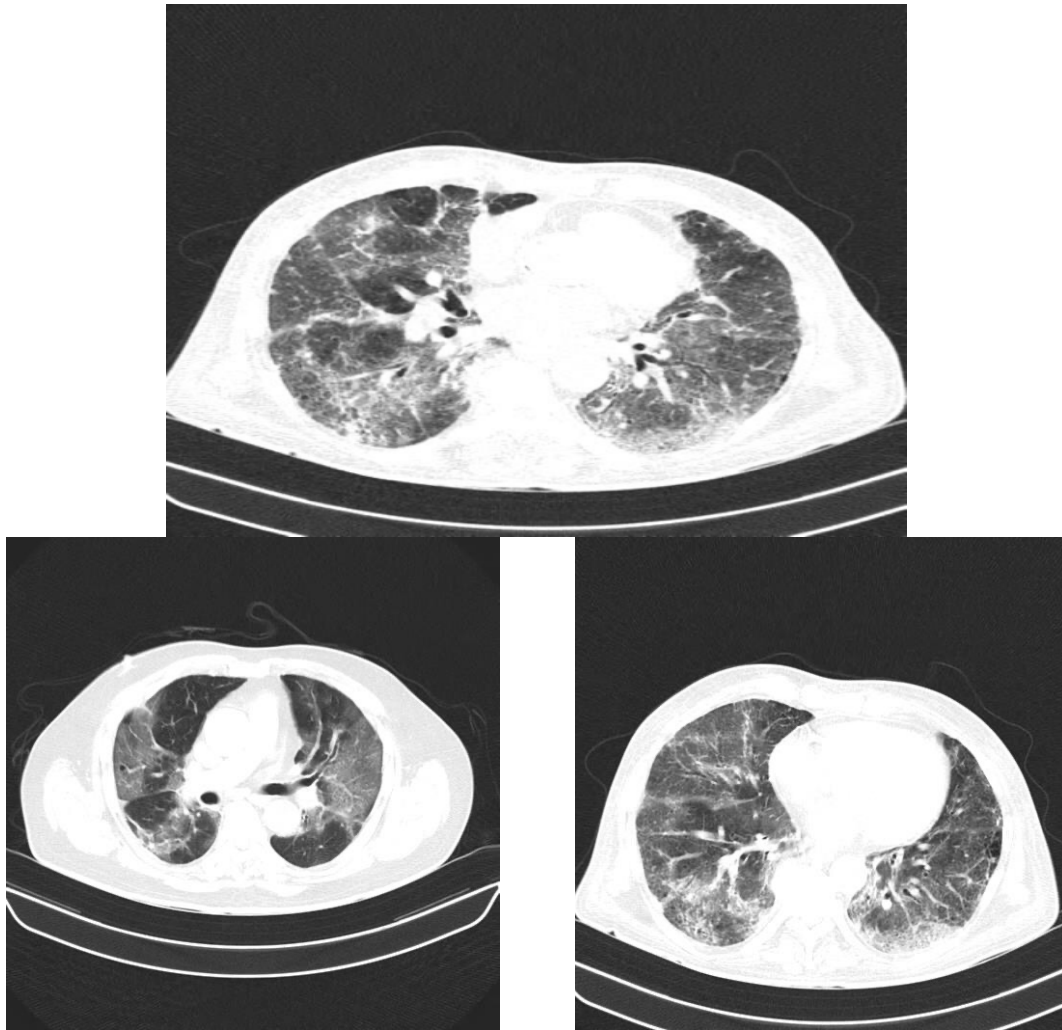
CT manifestations of covid19 disease a) ground glass opacities b) consolidation c) consolidation with ground glass opacity [31]
